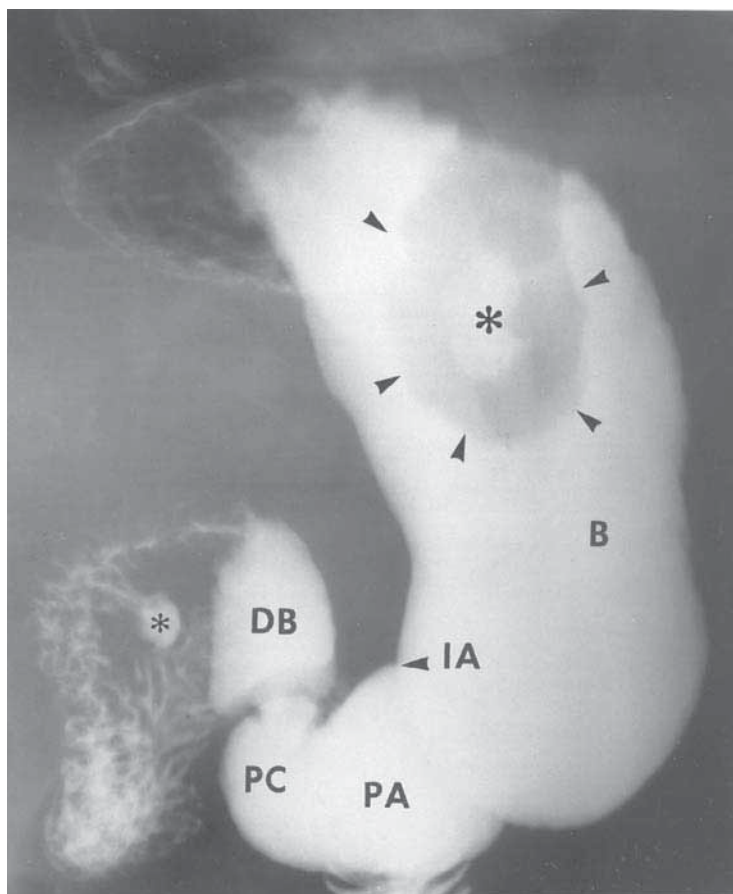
X-Ray of the Stomach Showing a Large Ulcer on the Posterior Wall
